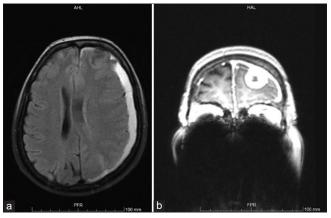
(a and b) Axial and coronal T2-weighted head magnetic resonance imaging confirming the presence of the left frontal lesion with adjacent subdural hemorrhage causing important mass effect and right midline shift.
